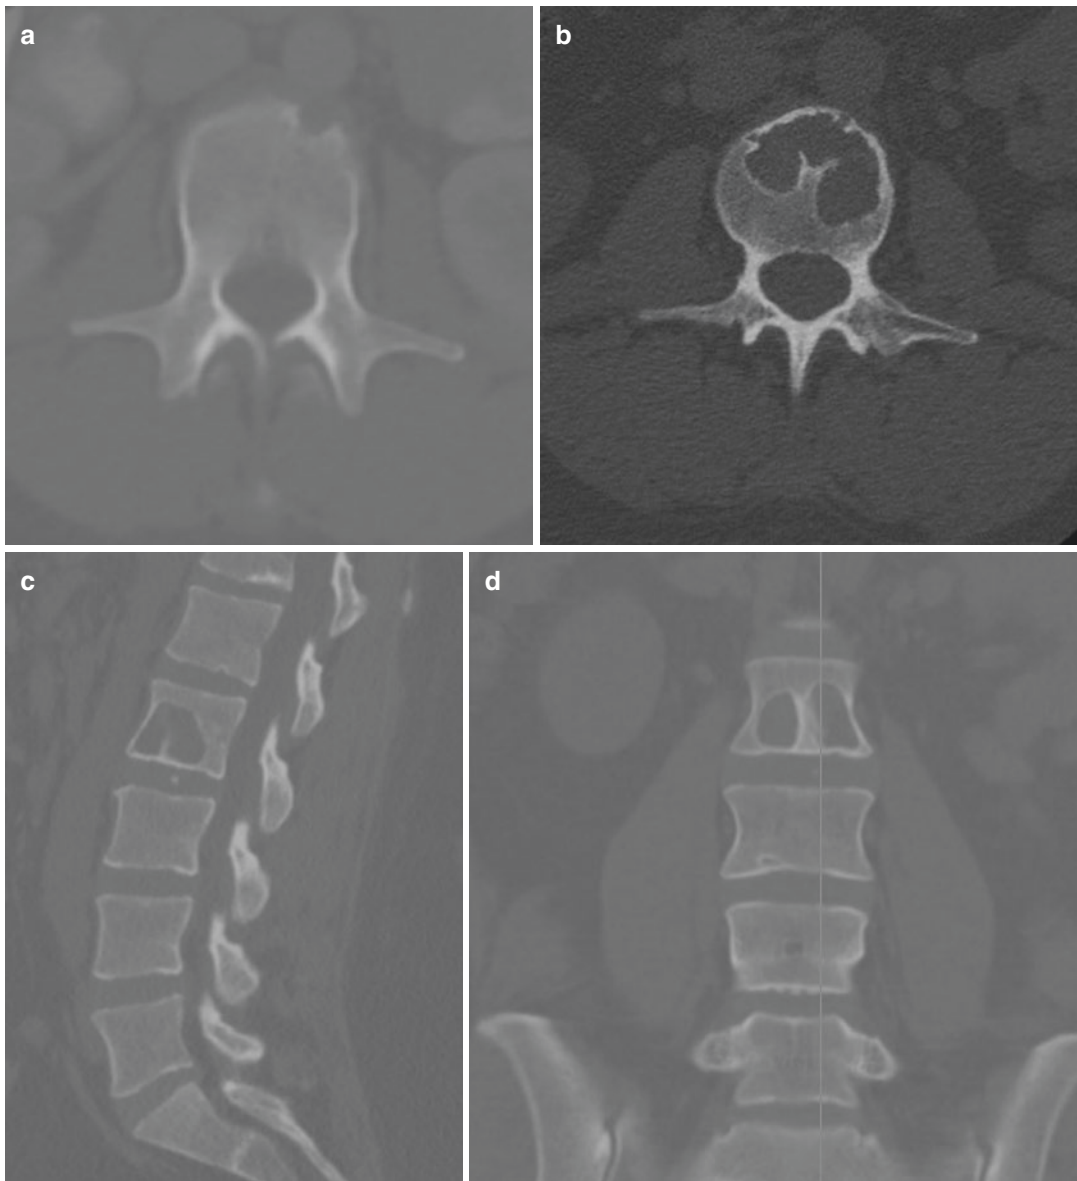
The CT scan images of the L2 vertebral 6 years prior to presentation (a; axial) and at the time of presentation (b; axial, c; sagittal, d; coronal)
